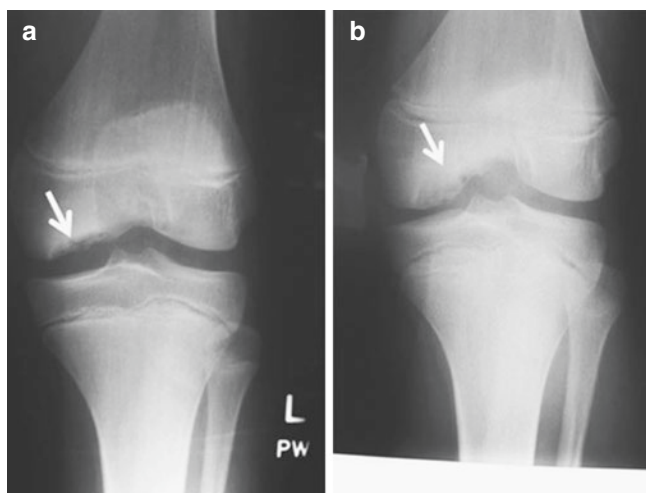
Osteochondritis dissecans. Radiographs of left knee (a) anteroposterior, (b) notch view, showing osteochondral defect on the medial femoral condyle
